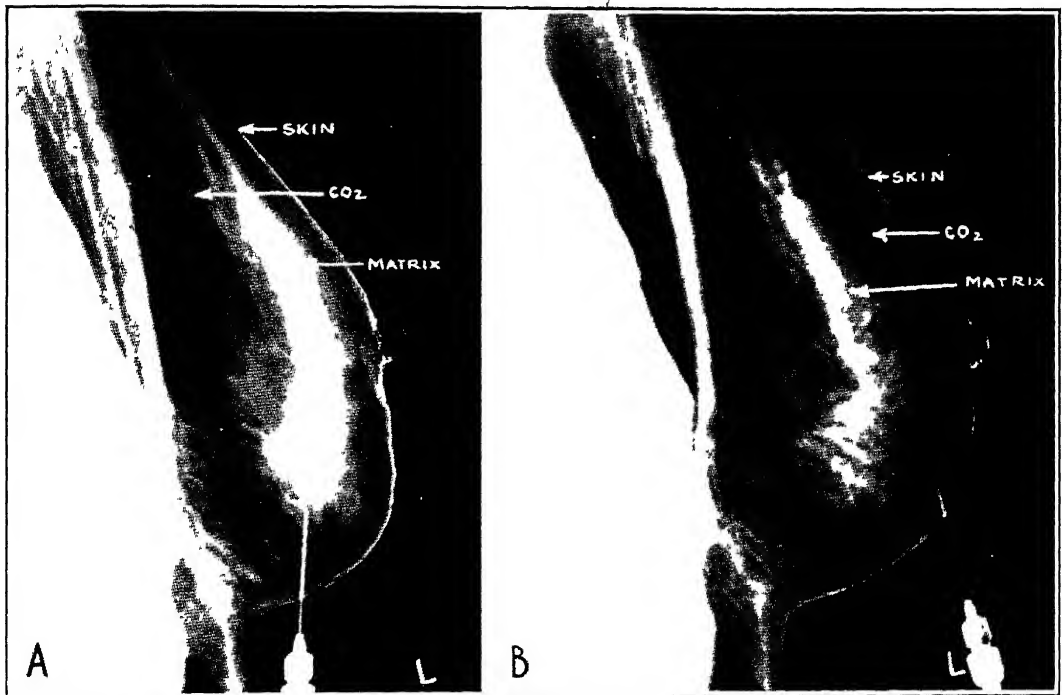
The retromammary, *A*, and the premammary, *B*, spaces are inflated with CO₂ until the gas completely surrounds the matrix tissue (Am J Roentgenol, March, 1938)
